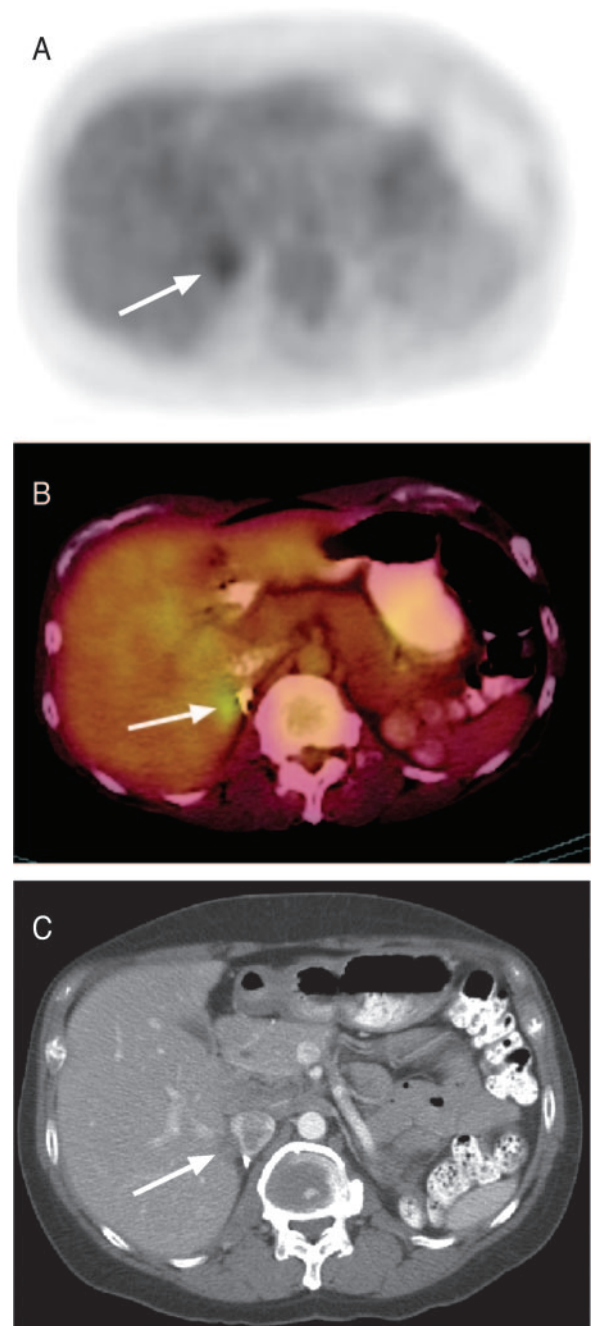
Patient 8, true-positive FDG PET. A and B, Transverse FDG PET images (A) and fusion image (B) from concurrent CT demonstrating mild activity in the right adrenal bed. C, This lesion is barely visible just adjacent to the inferior vena cava on contrast-enhanced CT. Surgery was performed to remove a small retroperitoneal focus of well-differentiated ACC invading the liver adjacent to the inferior vena cava.
